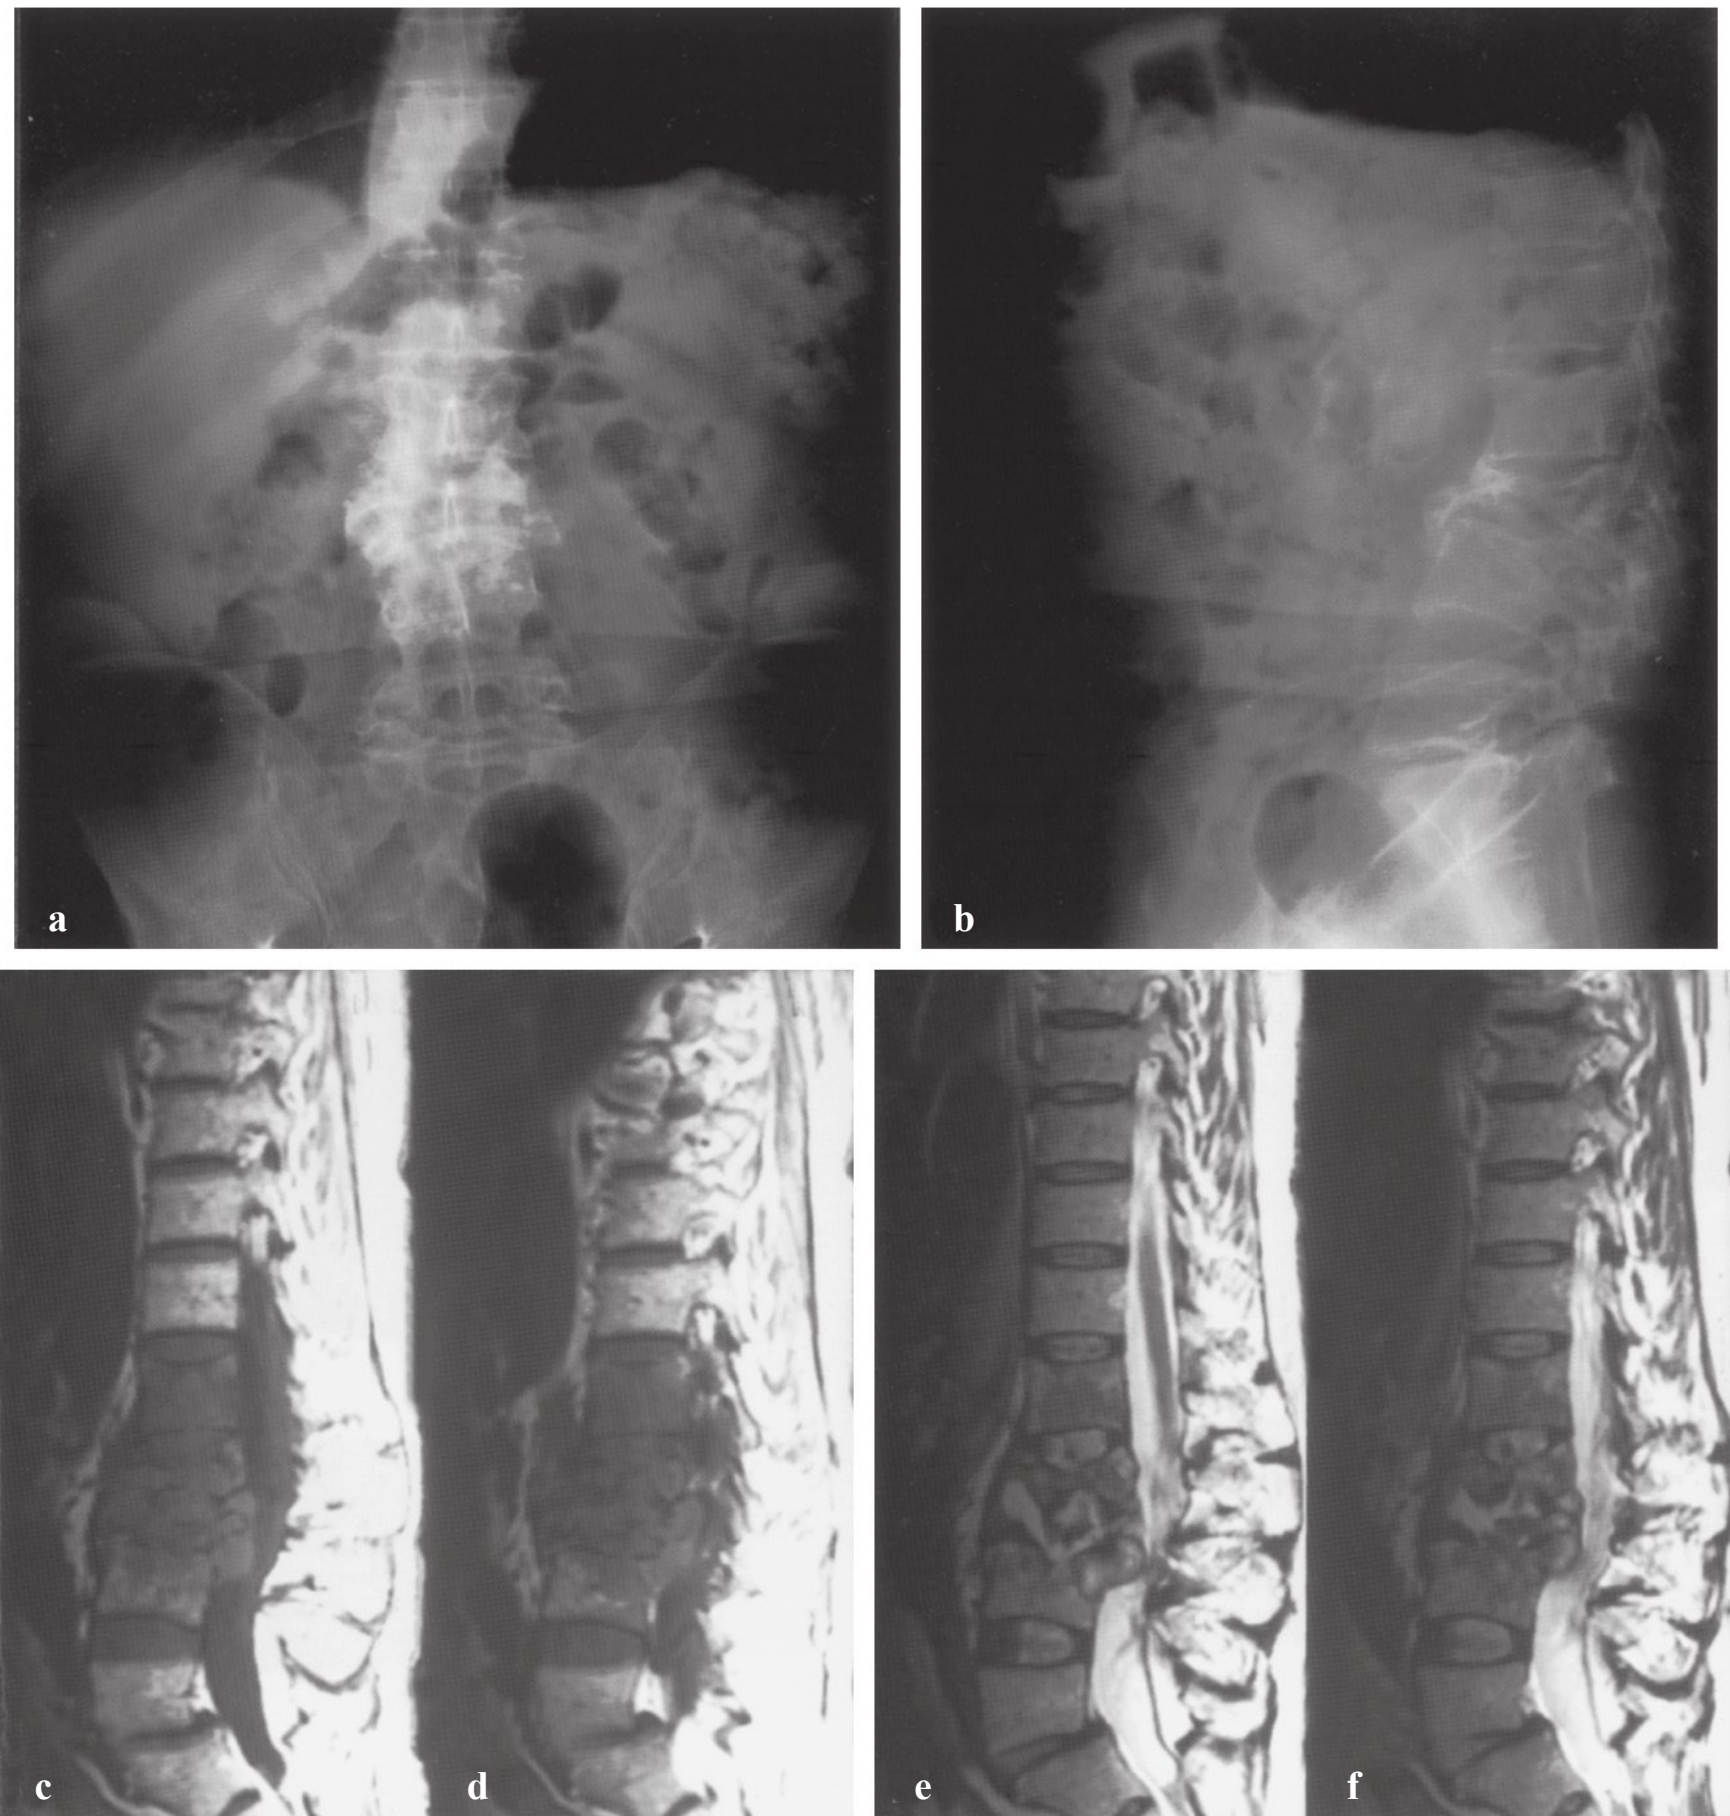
Tuberculosis of the lumbar spine. A 52-year-old man with disseminated tuberculosis was treated with 1 year of therapy with three antituberculous drugs. He presented with progressive low back pain and neurogenic claudication. (a) Anteroposterior and (b) lateral lumbar spine radiographs show collapse of L2 and L3 with kyphotic deformity. (c,d) T1-weighted image sagittal magnetic resonance imaging (MRI) sequence demonstrates decreased signal in the bodies of L1 to L4, kyphotic deformity, and epidural mass composed of necrotic bone, disk, and purulent debris. (e,f) T2-weighted sagittal MRI sequence demonstrates areas of high signal intensity within the L2 and L3 vertebral bodies and in the anterior paraspinal region.
